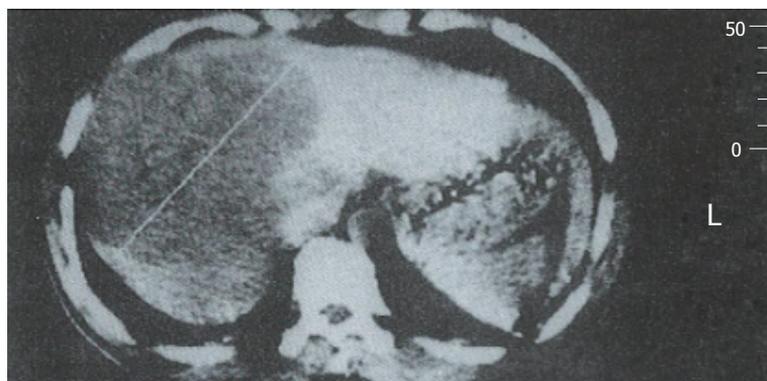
Prior to HAE with Lp MMC and BS powders, a CT scan of the massive PHC showed local low density in the right hepatic lobe.
